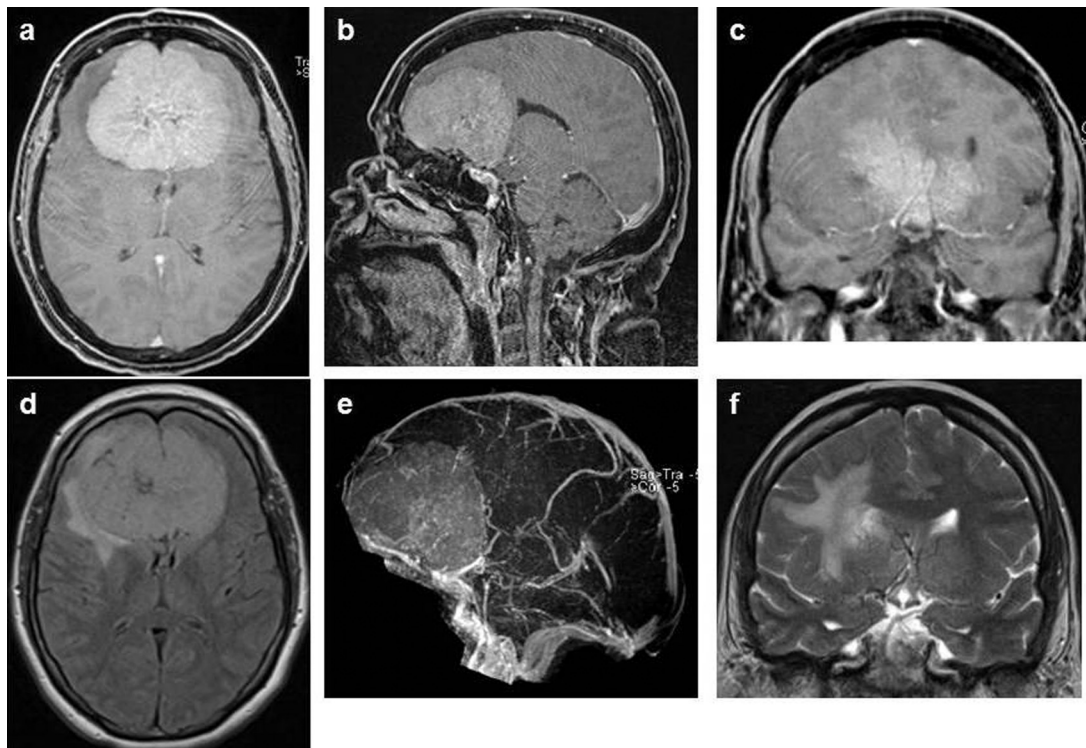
Presurgical MRI. (a–c) Representing contrast enhanced T1 images on axial, sagittal and coronal planes. (d) The T2 flair axial plain, (e) the MRI angiography reconstruction and (f) a coronal T2 section. It appears noticeable the intimate relationship of the lesion with the head of caudate nuclei bilaterally, as visible on axial post contrast T1 and particularly on T2 Flair images. The coronal sections are particularly useful to show the spatial relationship between the lesion and the basal ganglia (c) and the pushing effect on the aforementioned structures (f). The sagittal plane (b) enables us to show the distortion of brain tissue just adjacent to the thalamus. (e) Summarises the entire lesion and its complex vascular relationships.
